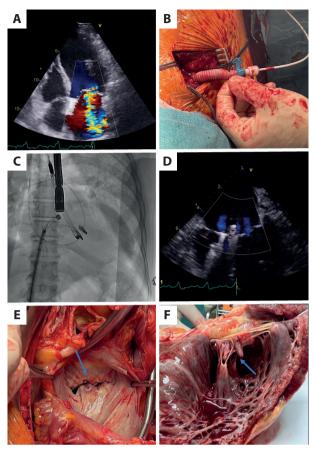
A. Transthoracic echocardiography, severe mitral regurgitation. B. Impella 5.5 implanted through axillary access with a surgically inserted Dacron graft. C. MitraClip implantation (angiographic view with previously implanted Impella 5.5). D. Transesophageal echocardiography, mitral regurgitation reduction after two MitraClip devices implantation. E. Surgical atrial view, MitraClip devices marked with an arrow. F. Explanted heart, MitraClip devices marked with an arrow.
